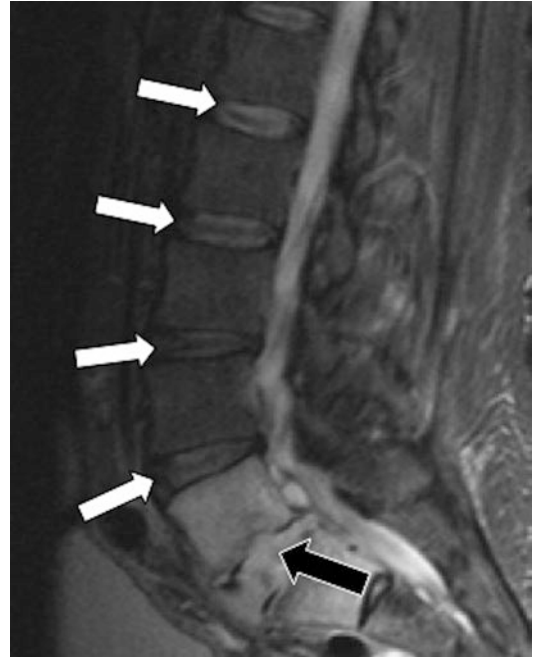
A 44-year-old male with pyogenic spondylodiscitis involving L5–S1. Sagittal STIR fat-saturated MR image demonstrates normal fibrous intranuclear clefts (white arrows) within the uninvolved intervertebral discs. The intranuclear cleft at L5–S1 is effaced (black arrow)
